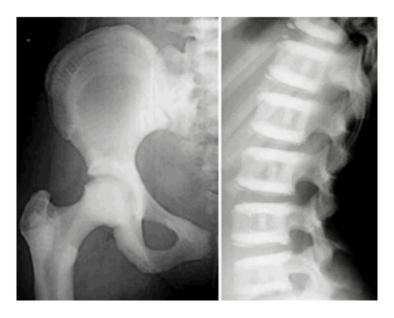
Autosomal dominant osteopetrosis type II radiographs Reprinted from Bénichou et al [2000] with permission from Elsevier
